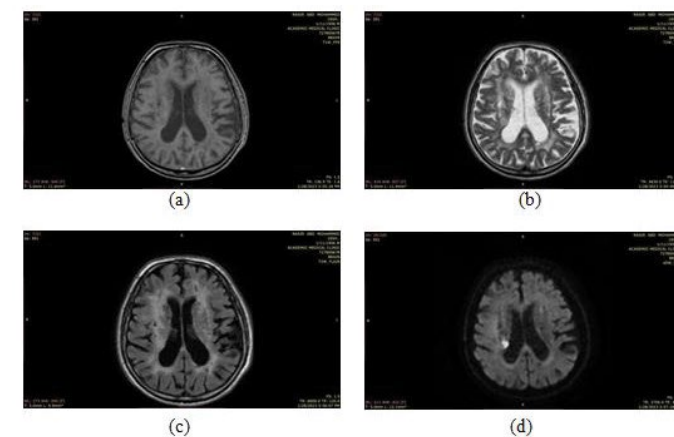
States the chronic stroke taken by (a) (T1W) sequence, (b) (T2W) sequence, (c) (FLARE) sequence, (c) (DWI) sequence.
